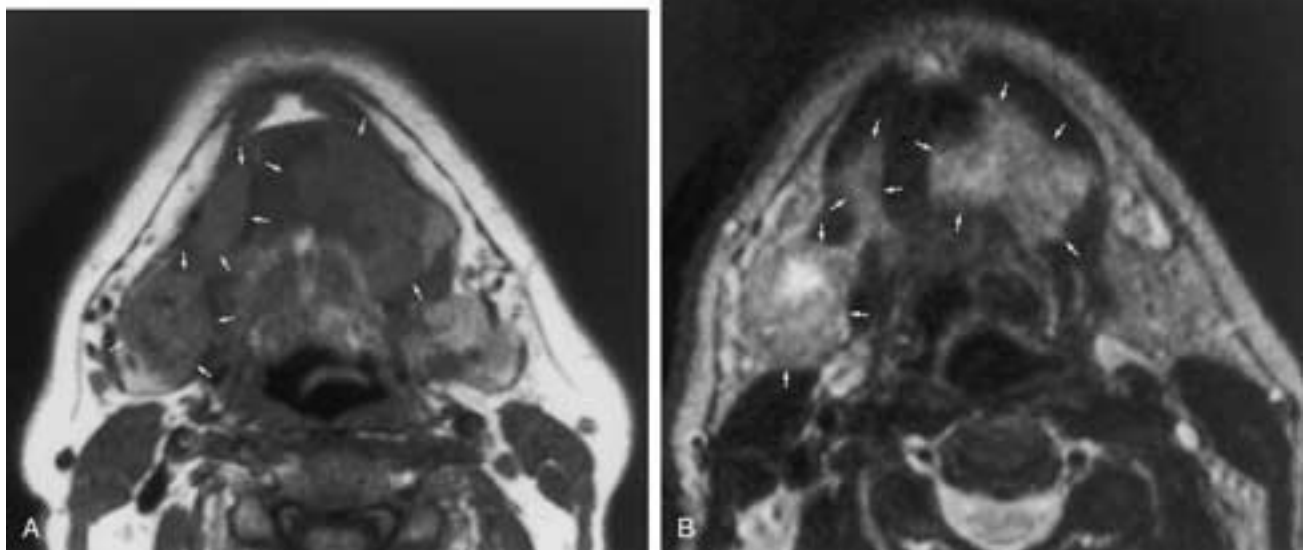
Rhabdomyomas. (A) Axial T1-weighted and (B) axial T2-weighted MR images demonstrate multiple rhabdomyomas involving the oral tongue on the left, the right sublingual space, and the right submandibular region (arrows). The lesions are slightly hyperintense to muscle on A, becoming more hyperintense to muscle on B. Following the administration of contrast, there was faint enhancement of these lesions. The lesions are indicated by the arrows. (Courtesy of Dr. Jan Casselman.)
